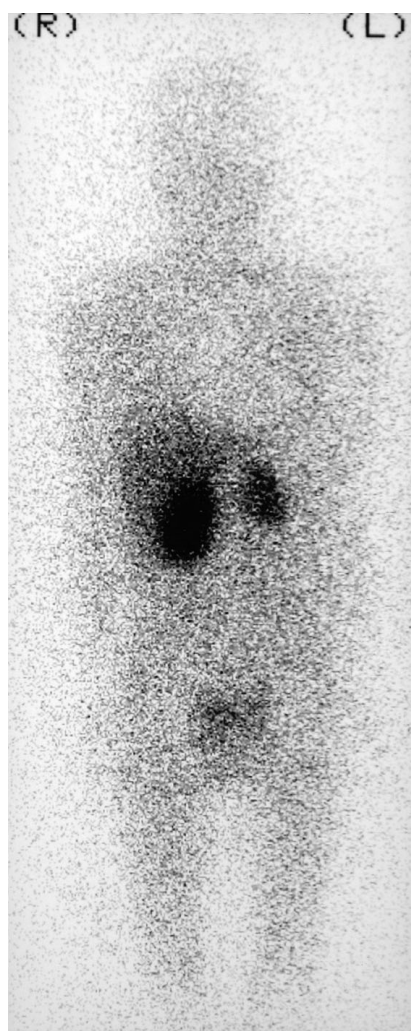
Iodine 131-labeled metaiodobenzylguanidine scintigraphy confirms bilateral involvement.
